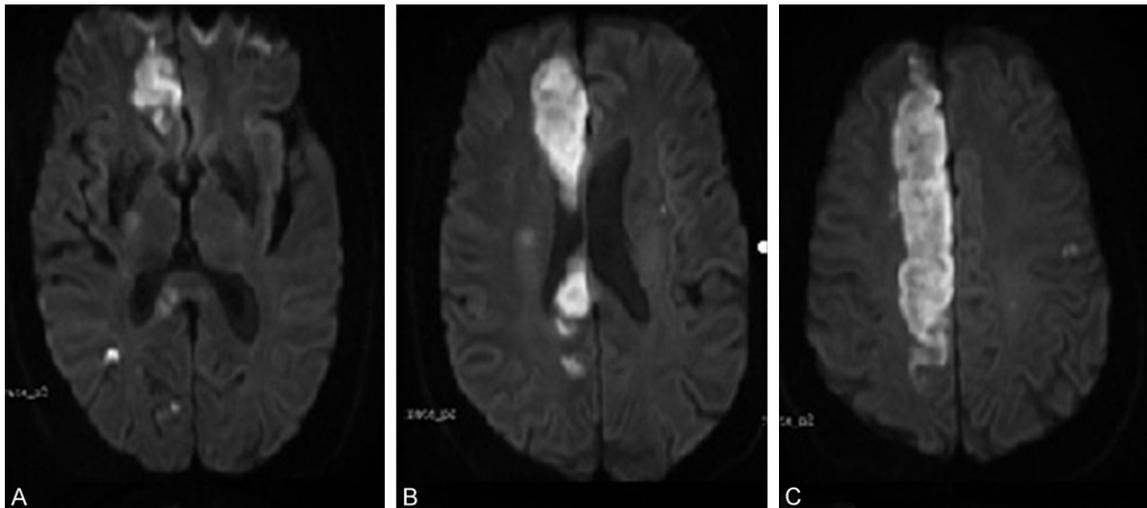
Cranial MRI diffusion weighted imaging (DWI) of Case 15. Multiple infarction lesions: 1 in right frontal and parietal lobes, 1 in left parietal lobe.
